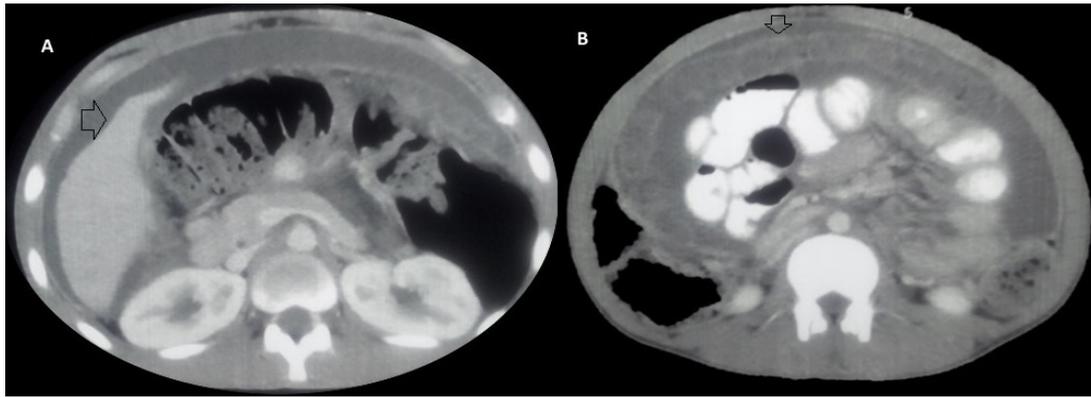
CT scan showing ascites, liver scalloping (A), and clumping of bowel loops with membrane (B). The arrow indicates liver scalloping (A) and a membrane surrounding the bowel loops (B). CT, computed tomography.
